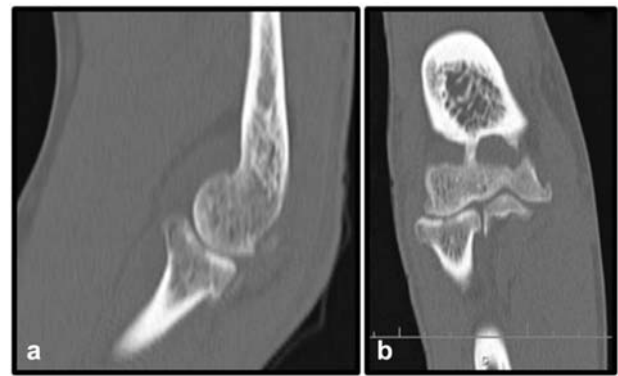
Computed tomography showed a non-displaced and isolated radial head fracture: sagittal (a) and coronal (b) views.
